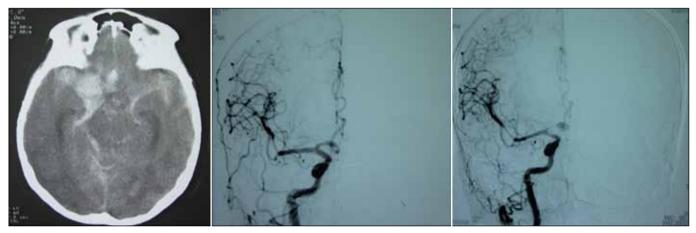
CT scan of a patient with NNSAH at admission revealed diffuse subarachnoid hemorrhage especially located on the right carotid cistern. The initial DSA was negative. On the repeat DSA investigation, right internal carotid artery injection showed a partially thrombosed, dissecting right A1 aneurysm.
